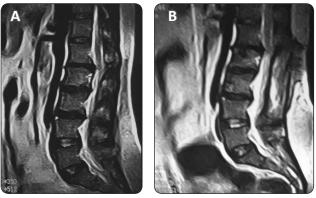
(A) Pre- and (B) post-operative sagittal MRI showing adequate decompression of the spinal canal.
